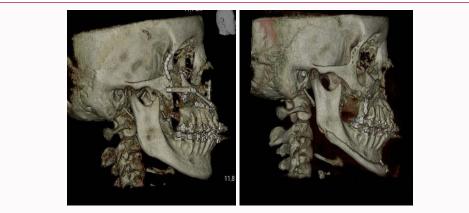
CT scan control pre- and post-palatine and facial distraction and mandibular basal total osteotomy.
